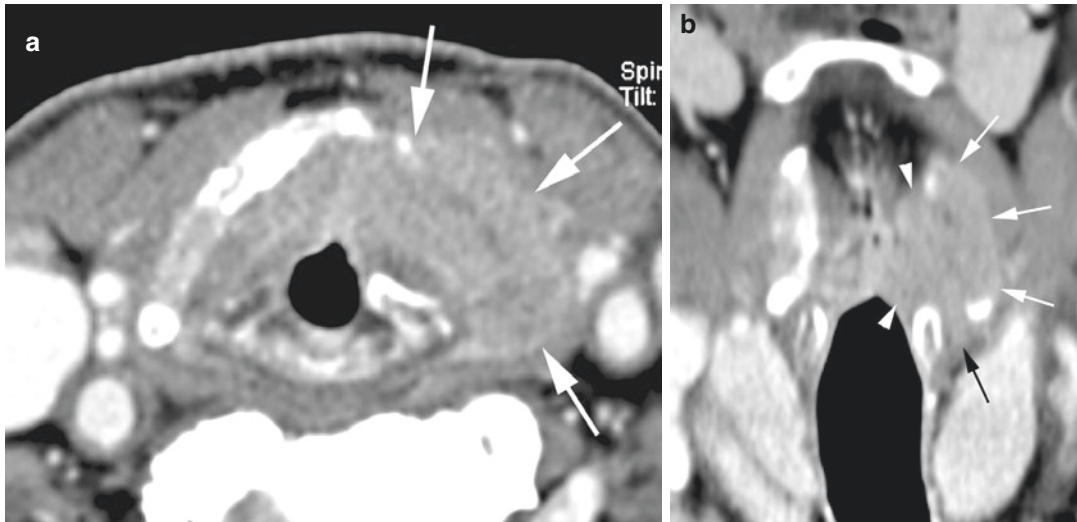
Contrast-enhanced CT images in a patient with a large left-sided glottic squamous cell carcinoma. (a) Axial image. The tumor mass massively invades and destroys the left wing of the thyroid cartilage, growing into the extralaryngeal soft tissues (arrows). (b) Coronal reformatted.
